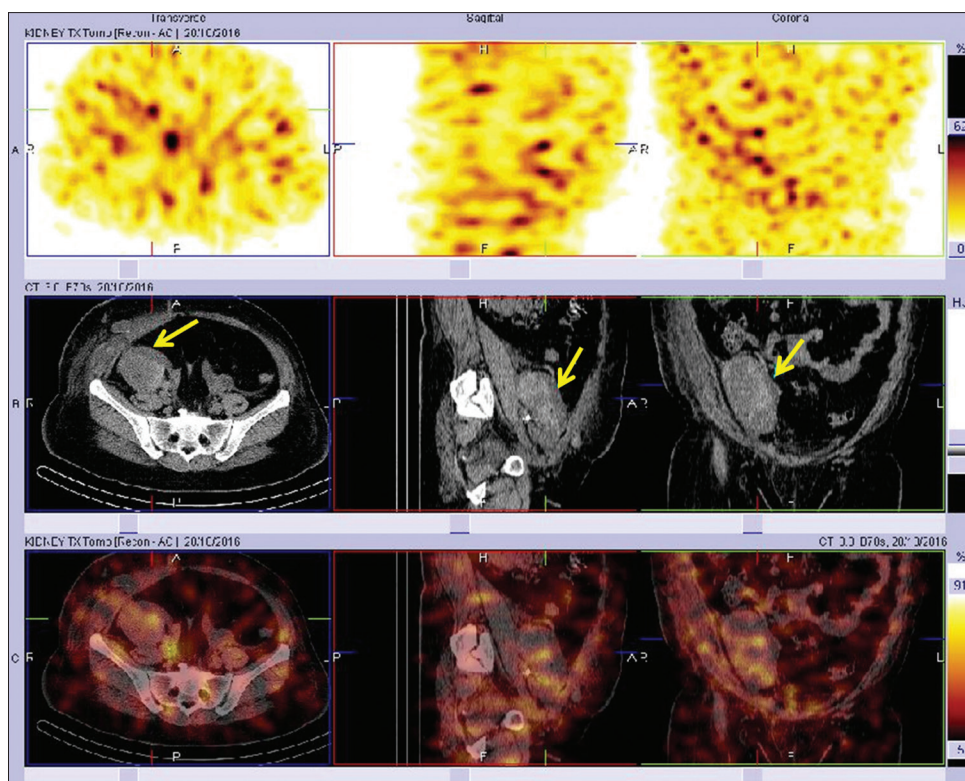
An immediate single-photon emission-computed tomography performed postcompletion of dynamic scanning revealed a large hypodense perigrraft collection suggesting a subcapsular hematoma (yellow arrow) raising the possibility of secondary hypoperfusion. Revisiting surgical notes revealed the use of robotic arm for harvesting donor kidney, suggesting a possible cause for hematoma development
